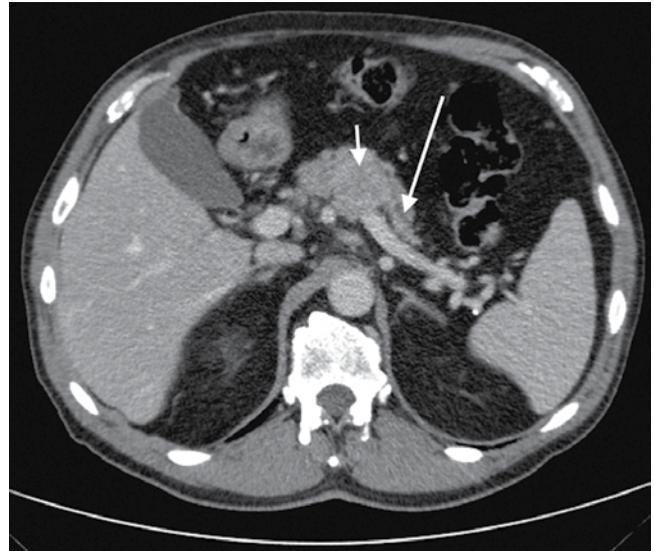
CT image showing pancreatic cancer (short arrow) causing obstruction and dilatation of the pancreatic duct upstream (long arrow).
